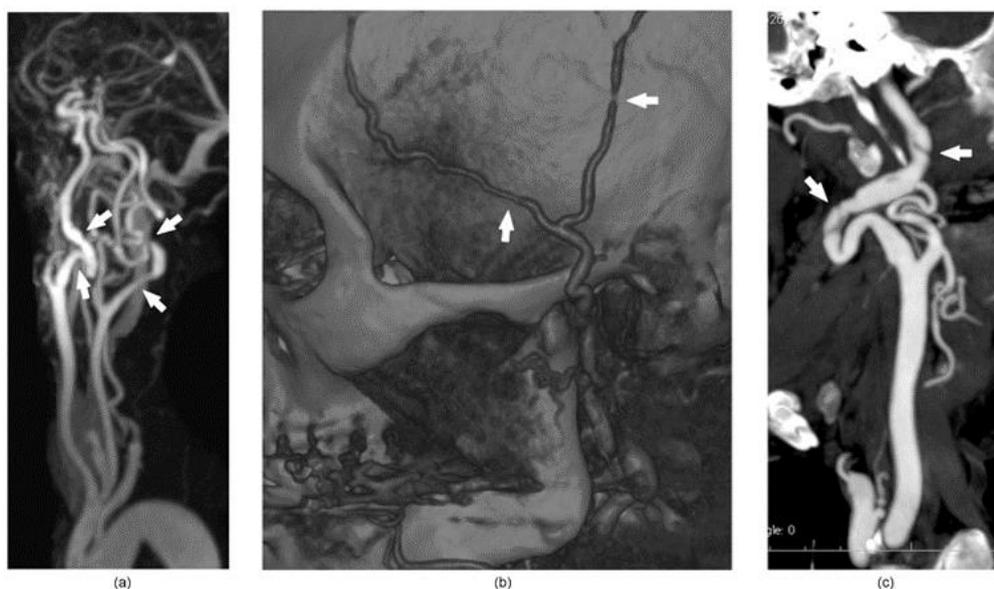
(a-c). Giant Cell Arteritis. Patient with severe worsening headache, diplopia and jaw pain. (a) At presentation, MRA demonstrates multifocal luminal narrowing and contour irregularity within bilateral internal carotid arteries (white arrows). (b) CTA volume rendering reveals multifocal short segment luminal narrowing of the superficial temporal arteries (white arrows). (c) Maximum intensity projection images of the internal carotid arteries with intraluminal linear defects (white arrows) are consistent with dissection. Abbreviations: MRA, magnetic resonance angiography; CTA, computed tomographic angiography. Courtesy of Adam Davis, MD.
